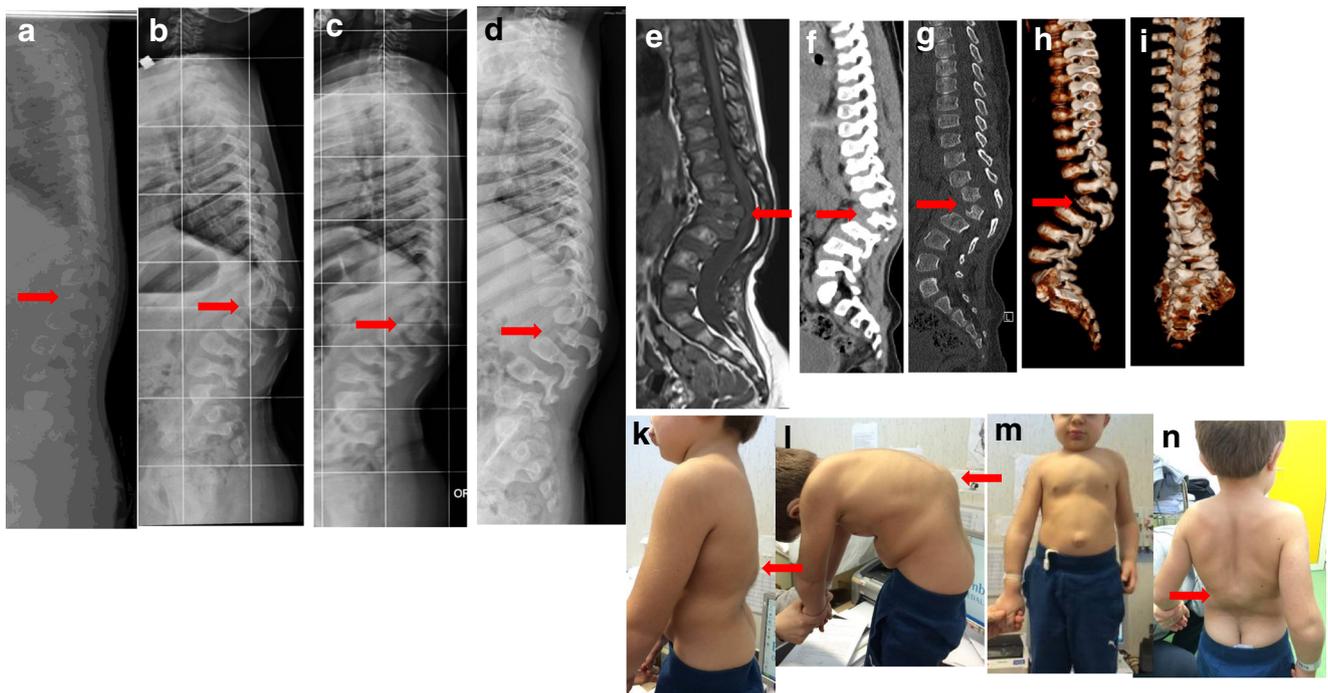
C.R. MPS I-affected boy, treated by haematopoietic stem cells transplantation; progressive thoracic lumbar kyphosis not responsive to brace; kyphosis progression, spine lateral X-ray at: a 10 months, b 3 years and 7 months, c 5 years, d 6 years and 1 month; e MRI showing L2
